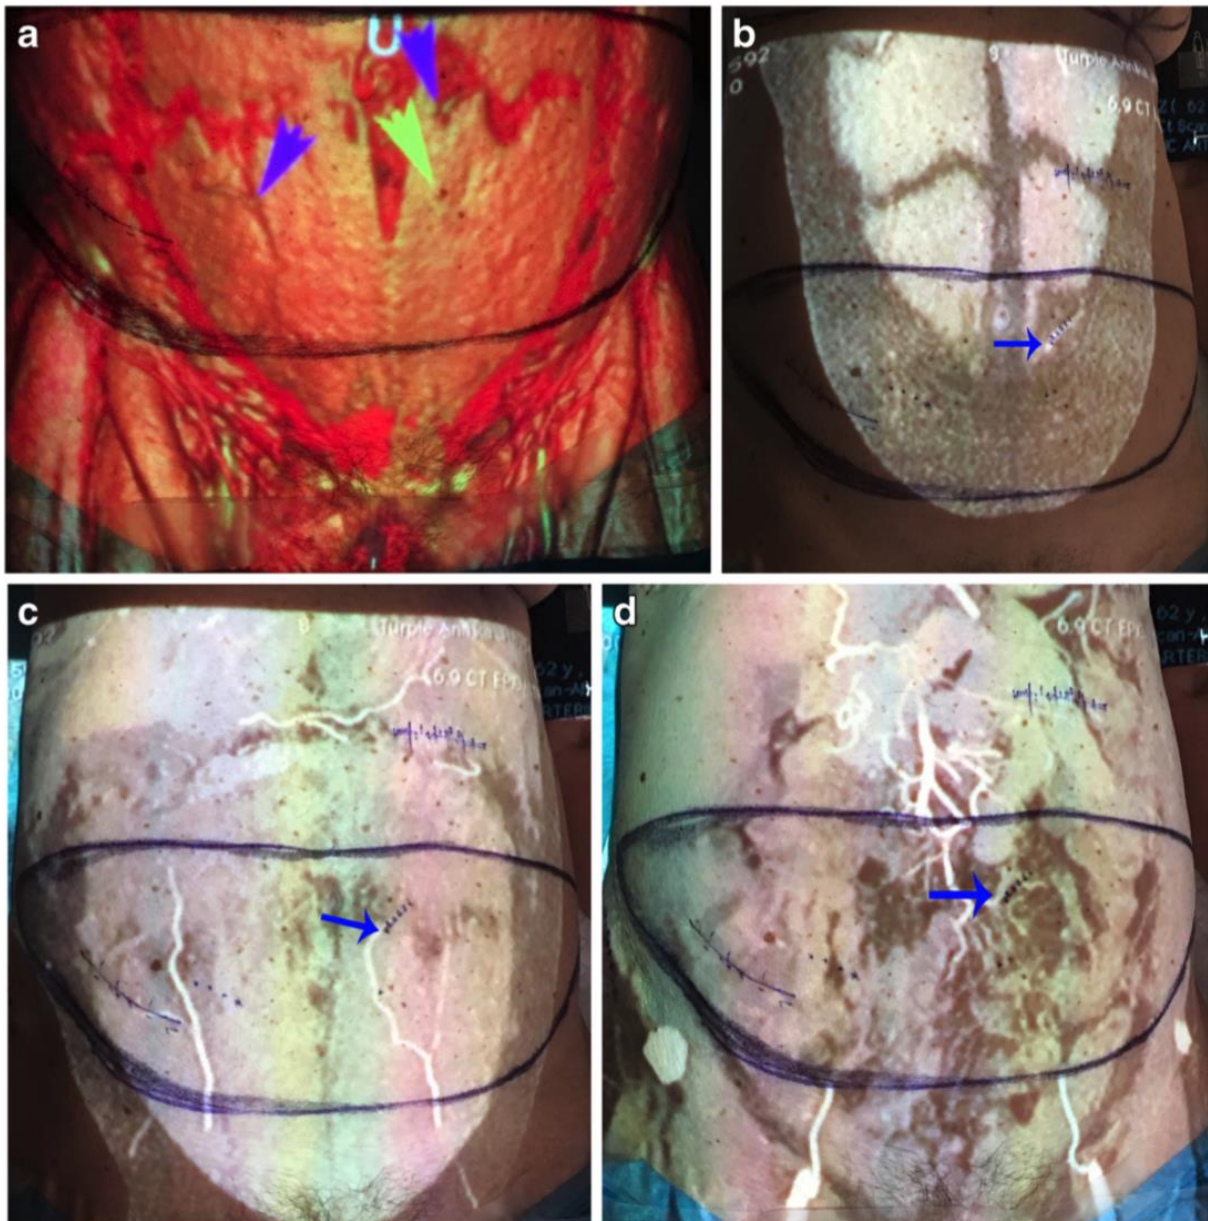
Direct augmented reality computed tomographic angiography technique (ARC) for deep inferior epigastric artery (DIEA) perforator (DIEP) flap planning. (A) Maintaining the same distance of the projector away from the patient at calibration, the 3D-reconstructed image of DIEA perforators is loaded on OsiriX software and projected onto the patient's abdomen, marking the cutaneous perforator location (blue arrow). Yellow arrows demonstrates smaller perforators. (B) A maximum intensity projection (MIP) reconstruction view of the perforator is projected onto the patient's abdomen to show the subcutaneous course of the perforator selected. (C) The same MIP reconstruction view of the perforator is used to show the intramuscular course of the perforator selected. (D) The same MIP reconstruction view of the perforator is used to show the source vascular pedicle.
